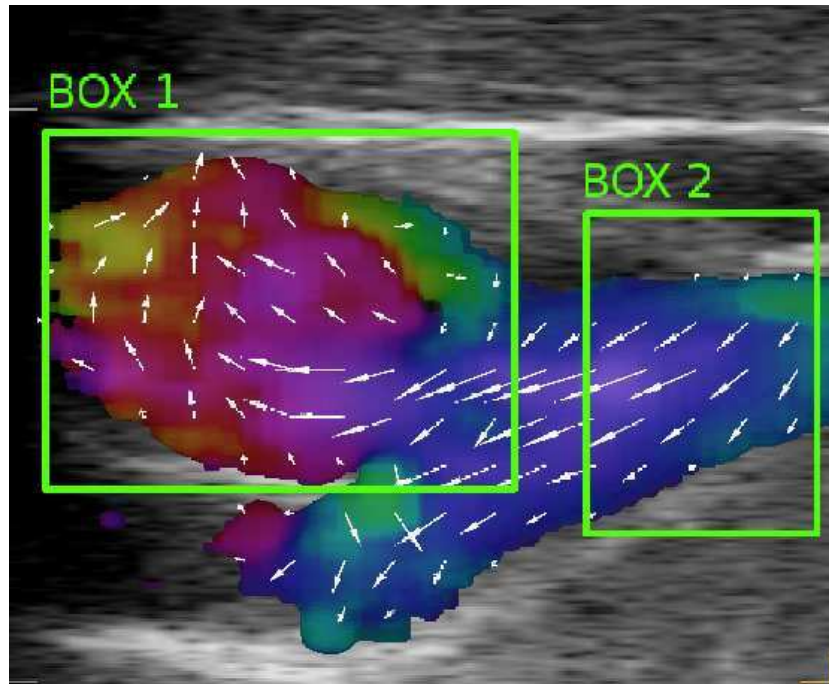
Vector flow ultrasound of the carotid bifurcation where the carotid bulb (box 1) and the common carotid artery (box 2) are outlined.*
